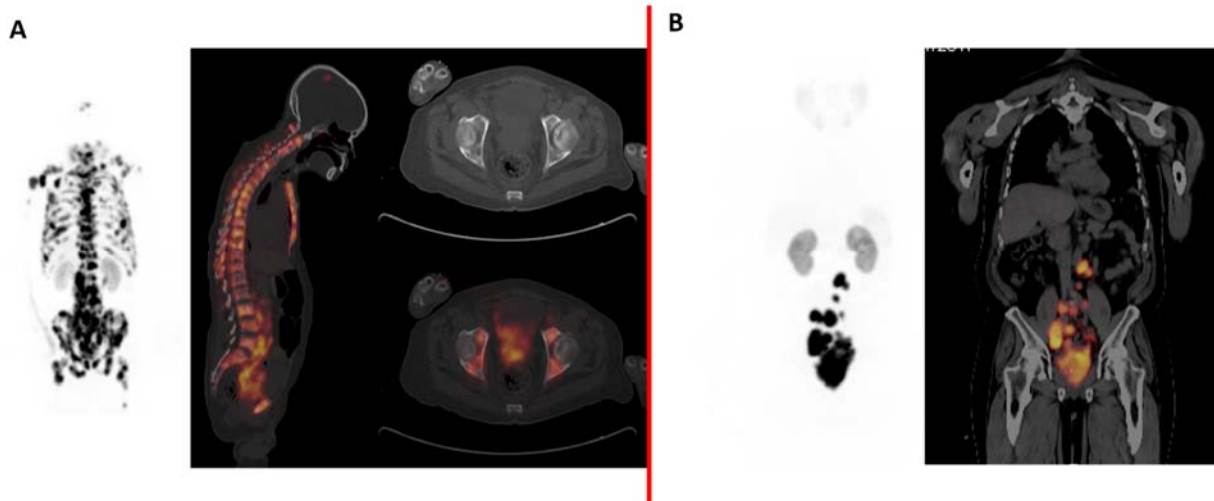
^{68}Ga -PSMA-11 PET/CT imaging obtained for initial staging in two patients with newly diagnosed metastatic prostate cancer. Patient A had a Gleason score of 4+4 and a PSA level of 104.8 ng/mL at the time of PSMA PET imaging, which shows locally invasive disease with widespread nodal and skeletal metastatic disease. Patient B was diagnosed with a Gleason 3+4 disease and a PSA of 47.1 ng/mL at the time of PSMA PET imaging, which shows locally invasive disease and a relatively low volume of metastatic nodal disease. Based on the differential burden of disease, patient B has a higher likelihood of a favorable survival outcome post-treatment compared with patient A.
